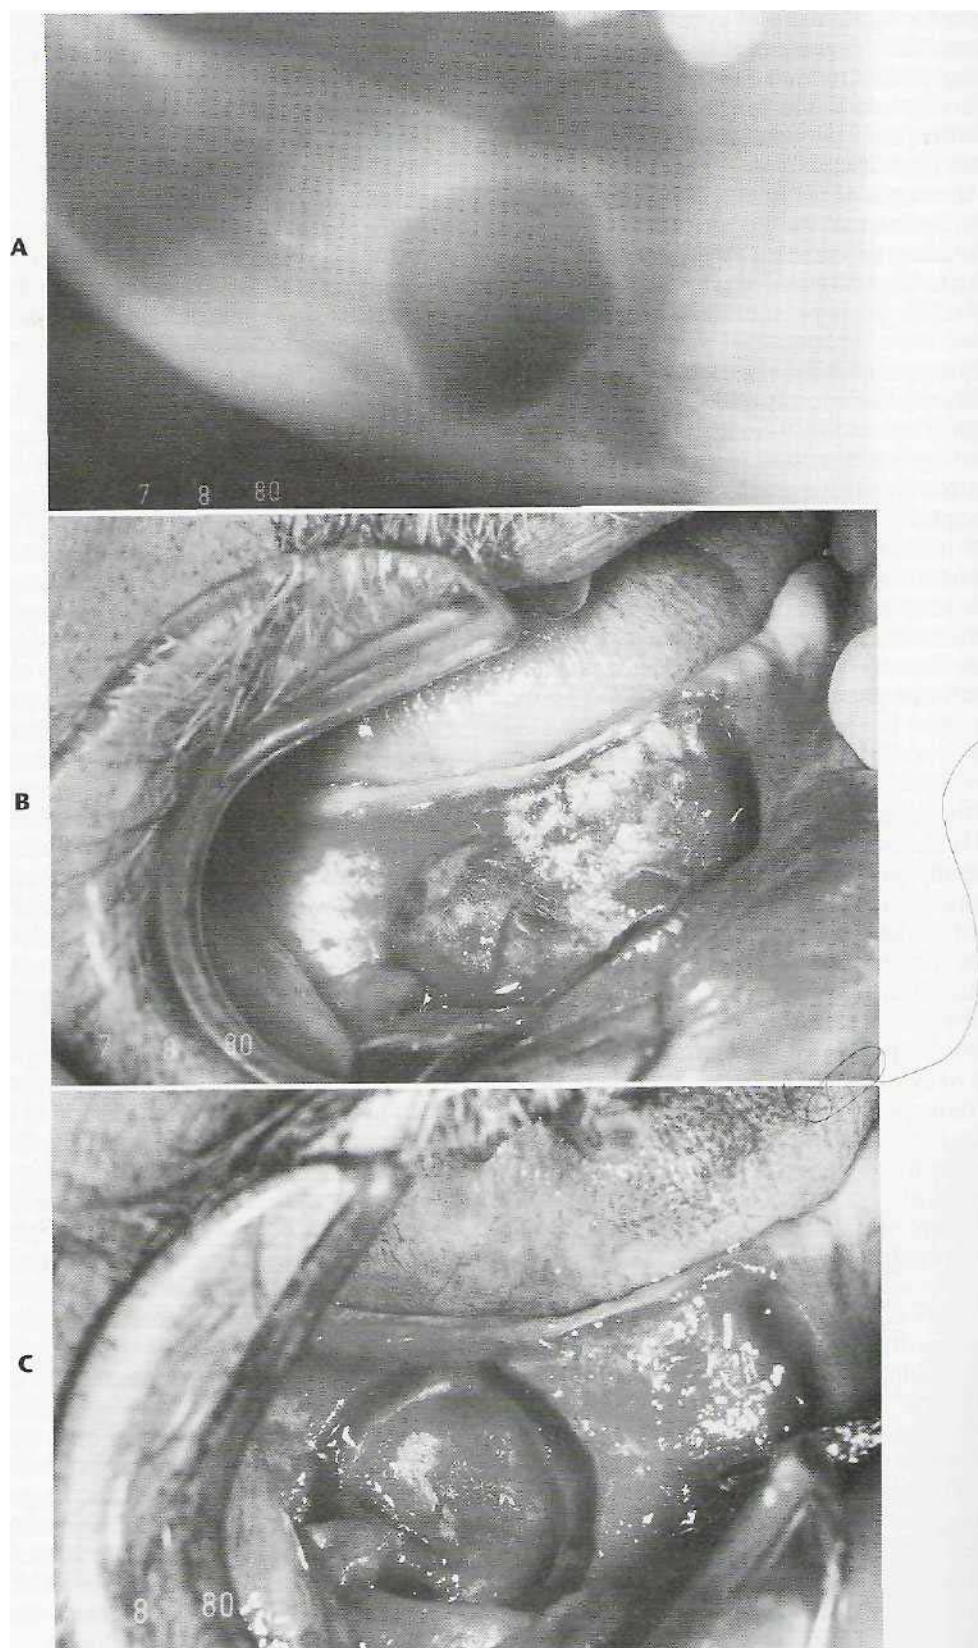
A, Typical radiographic appearance of cyst. Radiolucent center is surrounded by zone of reactive bone. B, Expansion of buccal bone caused by underlying cyst. The proximity to mental neurovascular bundle (on distal and inferior aspect of cystic expansion) is demonstrated. C, Cystic cavity after removal of cyst is visualized. Mental nerve is left intact. The amount of osseous tissue is destroyed by cyst.
